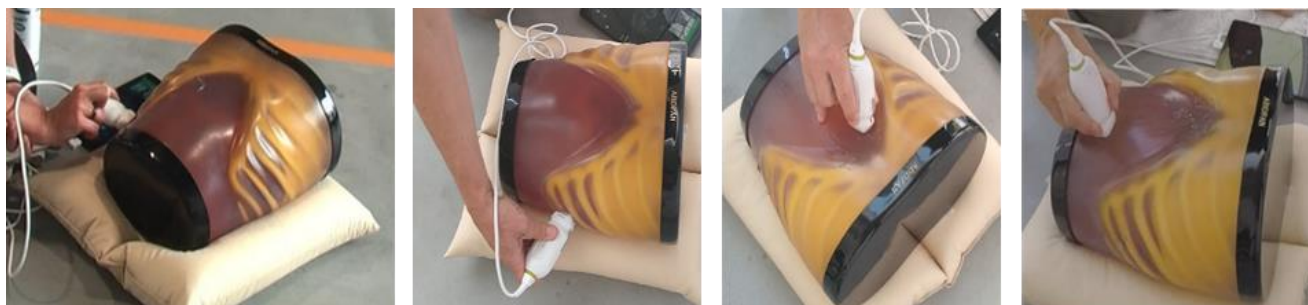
Probe positions required during ultrasound exams.
